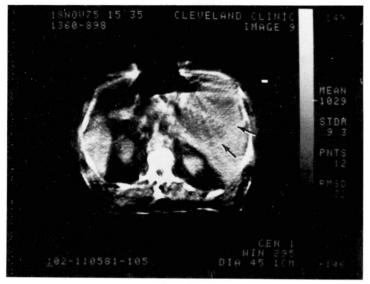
CT scan shows area of decreased attenuation representing intrahepatic abscess (arrows).
